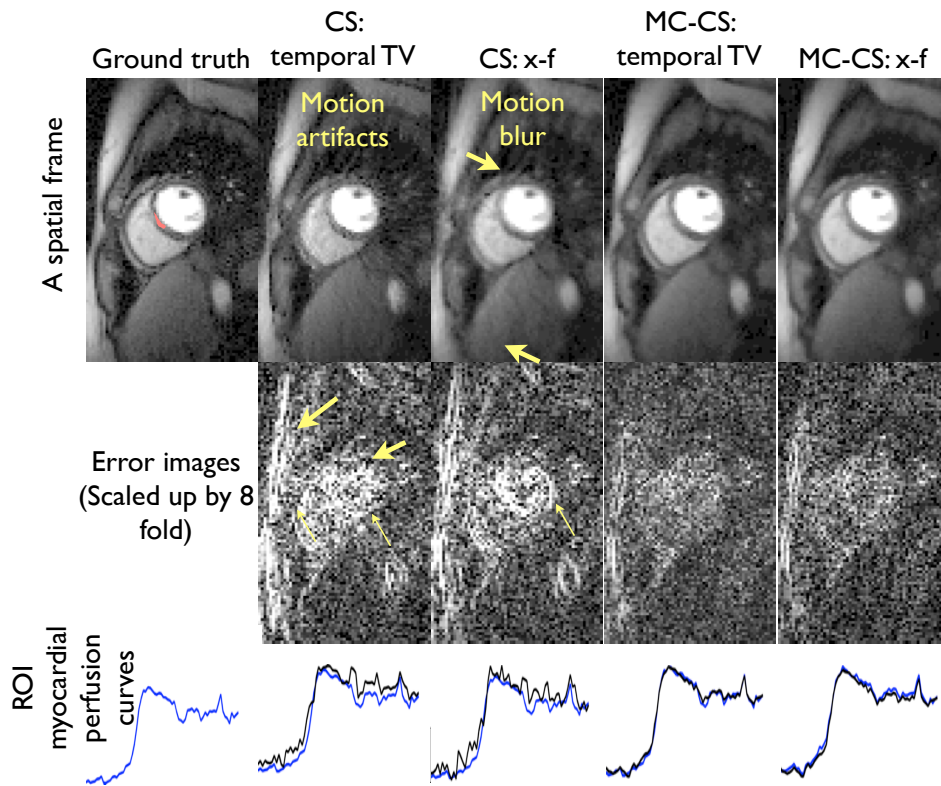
Recovery of a free breathing myocardial perfusion MRI data set from seven fold under sampled data using the deformation corrected compressed sensing algorithm. The joint estimation of the inter-frame motion along with the reconstruction greatly improves the fidelity to motion artifacts. Note the motion blurring and artifacts in CS reconstructions, in comparison to the motion compensated CS reconstructions (see arrows).
